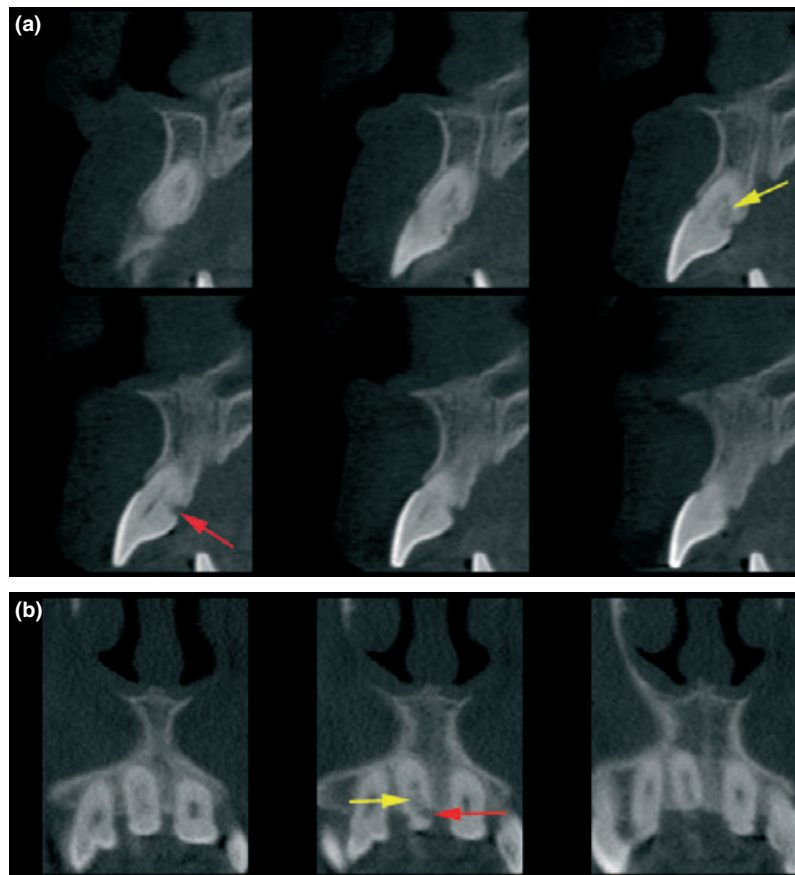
Cone beam computed tomograph scans. (a) Top, sagittal slices; (b) bottom, axial slices. The series of slices in both views clearly show two distinct areas within the resorptive lesion; outer inflammatory (red arrow), and an inner fibro-osseous (yellow arrow) resorption.
